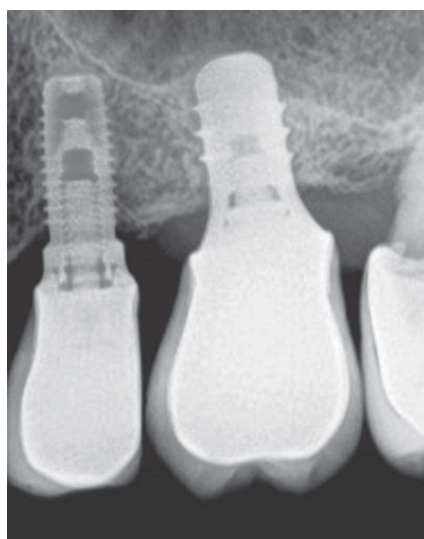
Digitized radiograph after five years. Note the Bragger index applied in the region.
